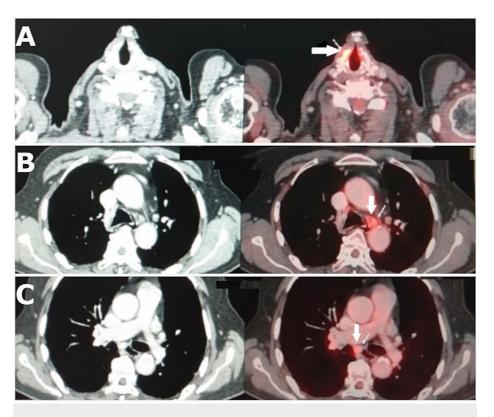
PET-CT for the spread of the carcinoma of the larynx
